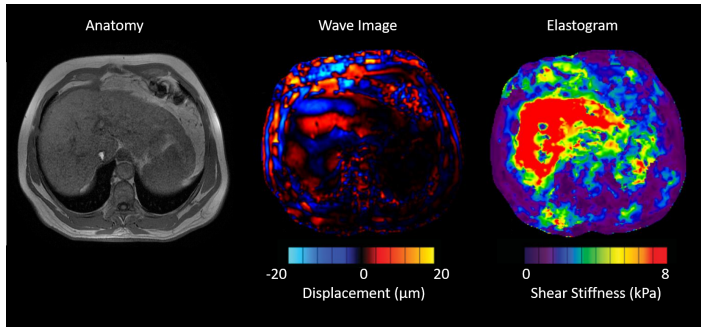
MRI and MRE images of the abdomen. From left to right: MR image, Wave image and Elastography image.
